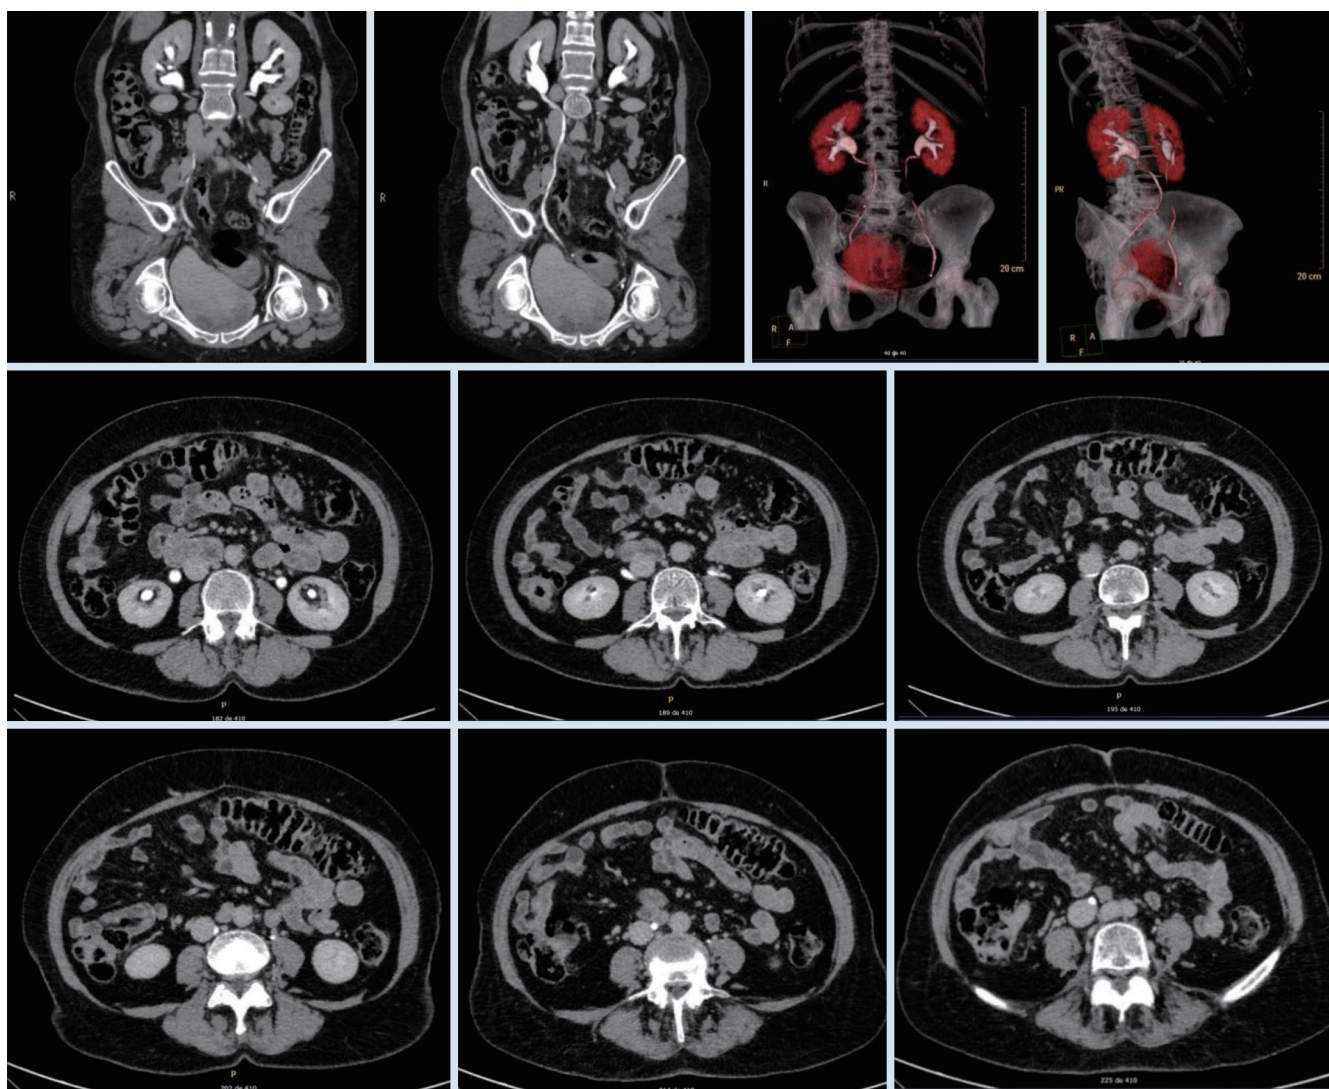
Computed tomography images demonstrating the right ureter circling the IVC with its distal portion following the expected route to the bladder. IVC, inferior vena cava.
